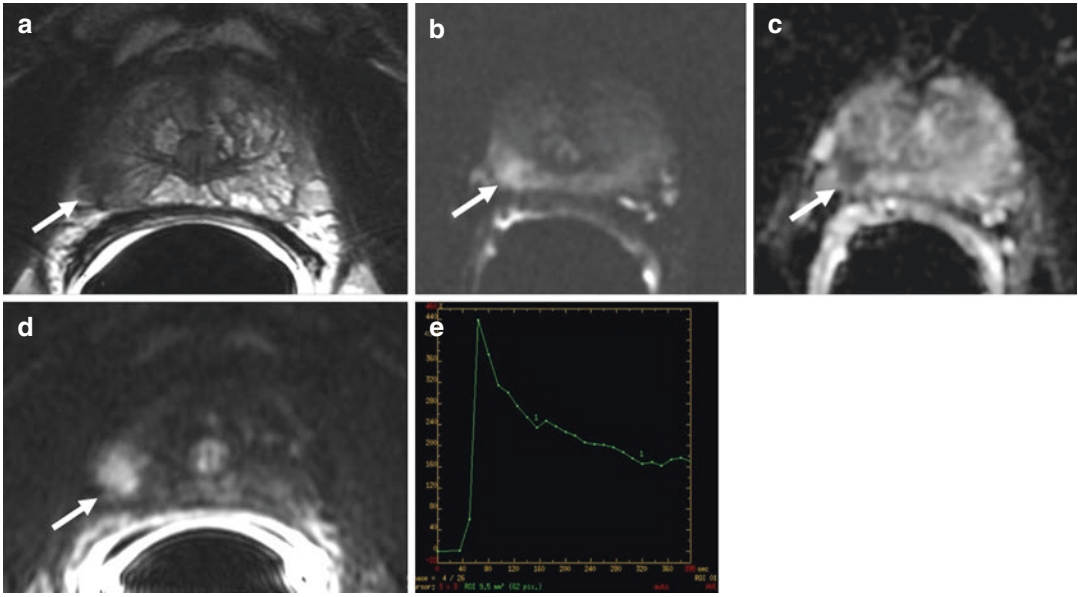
Images from a 59-year-old male with serum PSA 7.92 ng/mL, and one previous biopsy underwent an mp-MRI. The MRI demonstrated a PI-RADS 5 right posterior apex to mid-peripheral zone lesion (white arrow) on axial T2W (a), DWI (b), ADC (c), and DCE (d, e). MRI/US fusion software-based targeted biopsy demonstrated Gleason score 7 (3+4) prostate cancer (67% in three cores)
